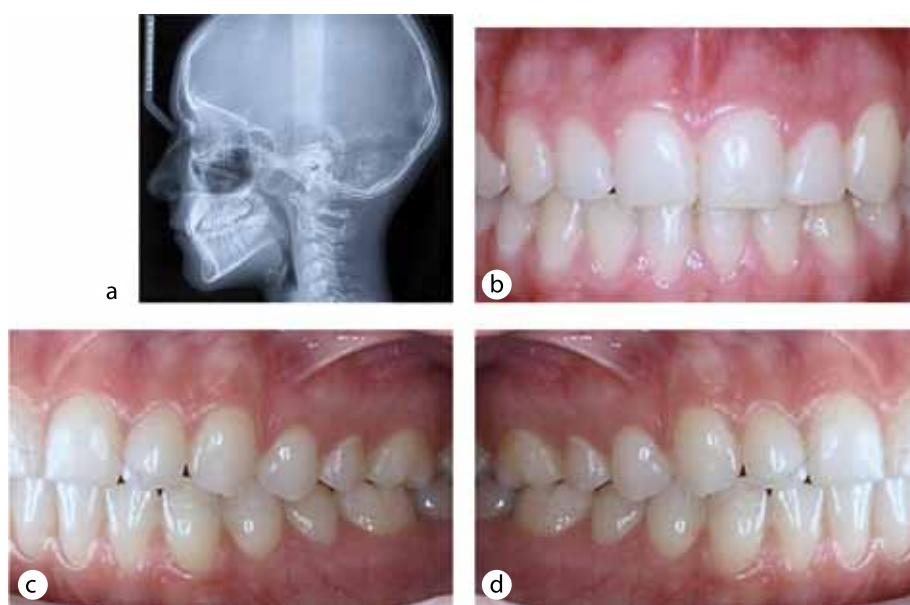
X-ray and photographic features of dental system, healthy patient K., 16 y.o. Head telereöntgenogram, lateral projection (a), physiological occlusion (b — direct projection, c — left-side lateral projection, d — right-side lateral projection)
